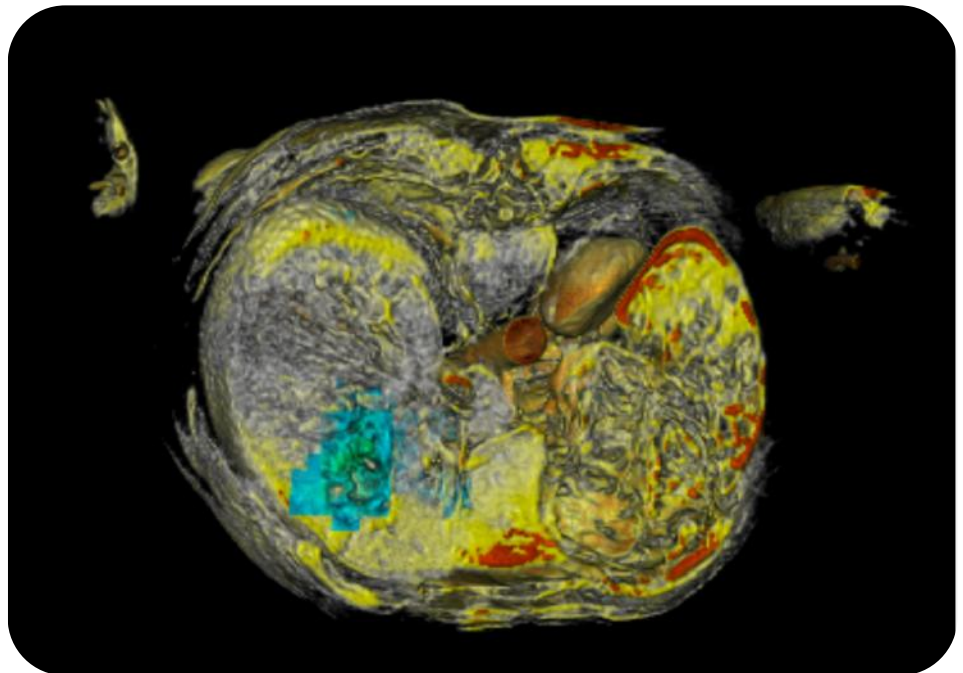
Classifiers applied to MRI test set A. MRI images has been inverted for an improved visualization.
